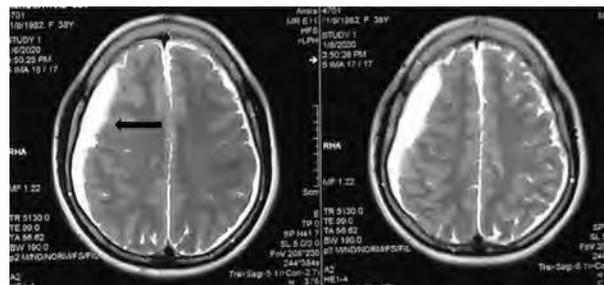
T2 Axial section MRI of brain - Increase in volume of subdural collection in right frontoparietal convexity and left frontoparietal, occipital convexity (follow-up scan).
